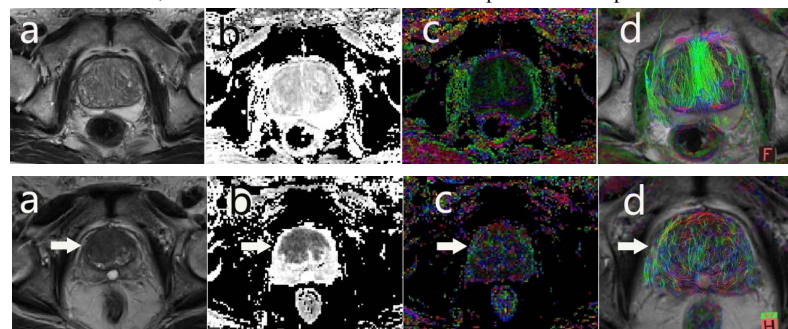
A 70 years old patient with BPH, PSA:5.46 ng/ml. a. Axial FS-T2 weighted MRI. b. ADC map. c. FA map. d. DTT map. The FS-T2 weighted MRI and ADC map showed multiple hypointense lesions in CG zone. DTT map demonstrated that fibers run orderly, continuously and arrange closely (rated 1 on four-point scale)
